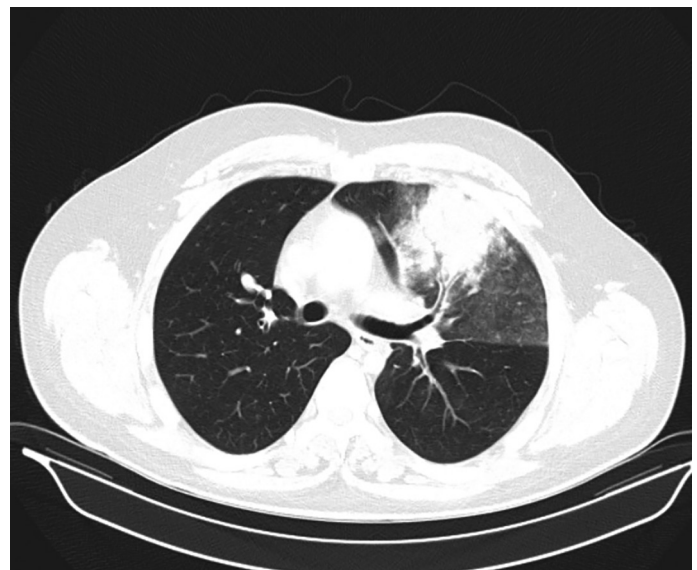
Computed tomography image of reperfusion injury in left lung after pulmonary stent implantation.
